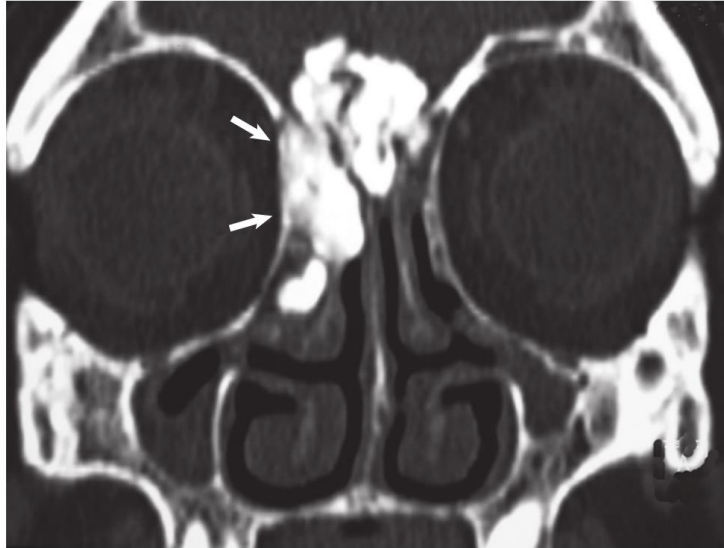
Osteoma on a coronal computed tomography scan. A huge ivory osteoma is shown in the right ethmoid, encroaching on the crista galli and the cribriform plate and invading the anterior cranial fossa. The right orbit is not invaded, and the thin lamina papyracea can still be detected (*arrows*).
